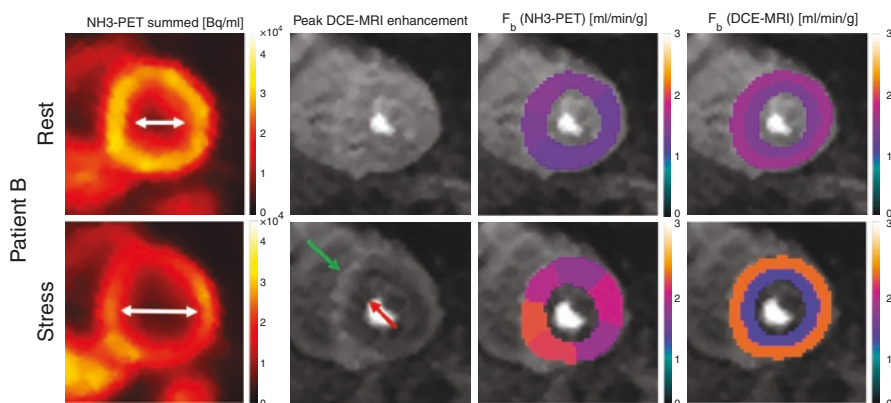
Simultaneous myocardial perfusion imaging using PET/MRI. This figure depicts a combined PET/MRI perfusion study of a patient with hypertrophic cardiomyopathy. On N-13 ammonia images a dilation of the left ventricle from rest to stress and a inhomogeneous myocardial perfusion during pharmacological stress can be observed. MR images demonstrate that this apparent dilation of the left ventricle is actually caused by a hypoperfusion of the endocardium during hyperemia. (Reprinted with permission from Kunze KP, Nekolla SG, Rischpler C, et al. Myocardial perfusion quantification using simultaneously acquired $^{13}\text{NH}_3$ -ammonia PET and dynamic contrast-enhanced MRI in patients at rest and stress. *Magn Reson Med*. 2018;00:1–14. <https://doi.org/10.1002/mrm.27213>)
